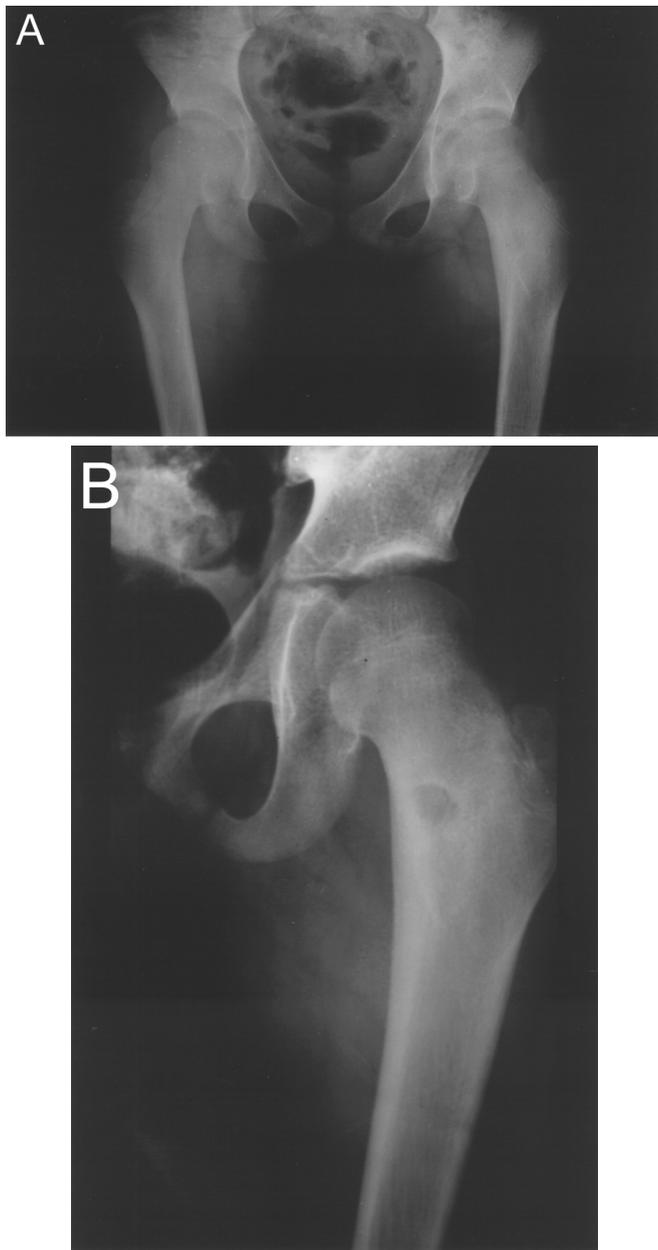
[A] Anteroposterior radiography of the left hip of a 10-year-old girl, showing osteoid osteoma in the femoral neck. [B] Radiograph of the hip of the same patient showing the size of the bone defect after removal of the osteoid osteoma.
